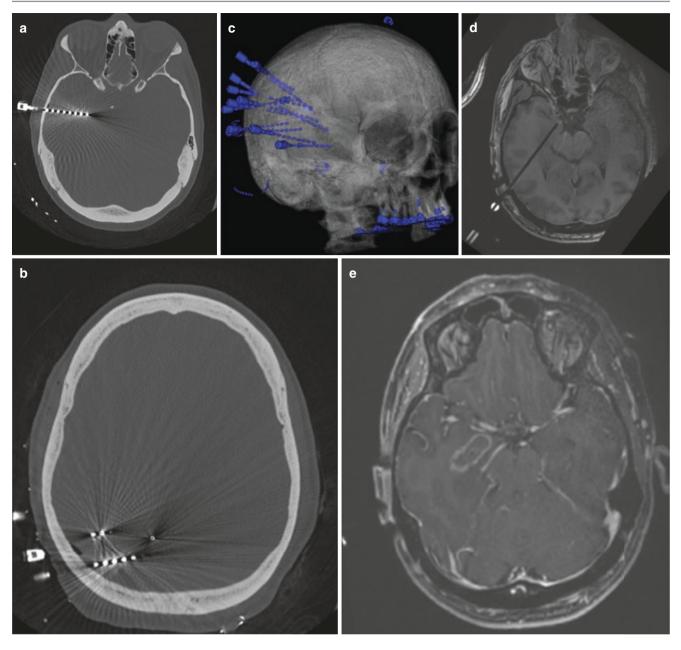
Same patient with further evaluation by SEEG to determine epileptogenic zone. Stereotactic head CT (a, b) and 3D reconstruction (b) demonstrate intracranial EEG lead placement in the right temporal and right parietal lobes, in the regions of clinical interest. Seizures were
